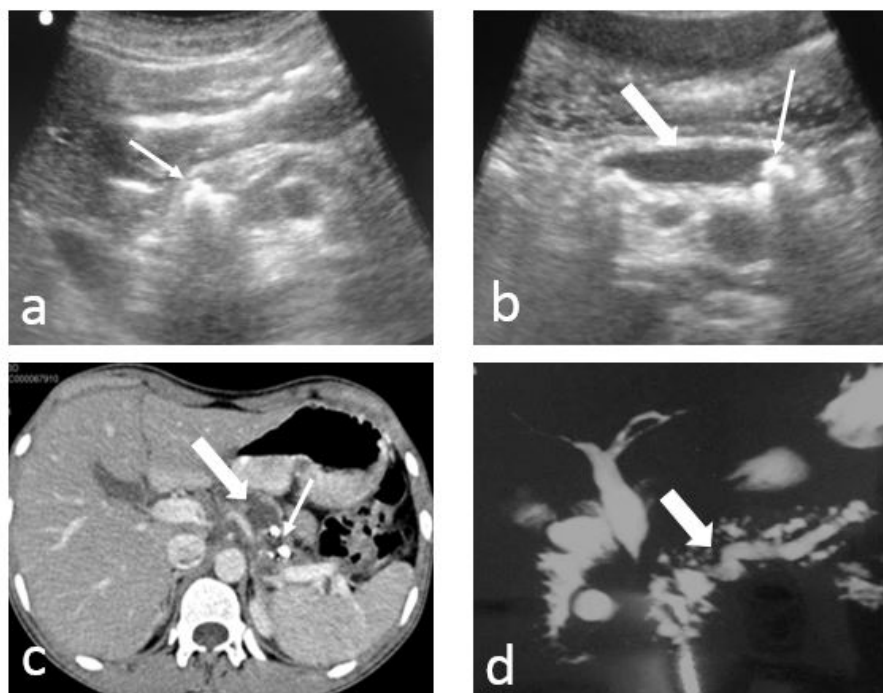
Transabdominal sonography images (a,b) show calcification (thin arrow) in the head and tail of pancreas with dilated MPD (thick arrow). Axial contrast enhanced CT image (c) also shows multiple intraductal calcifications (thin arrow) and dilated MPD (thick arrow). Heavily T2W thick slab MRCP image (d) shows irregularly dilated MPD and its side branches (thick arrow). Also a small fluid collection is seen in the region of head of pancreas and the common bile duct is dilated till the lower end with smooth tapering suggestive of benign stricture. The above findings are typical for chronic calcific pancreatitis (CCP).
